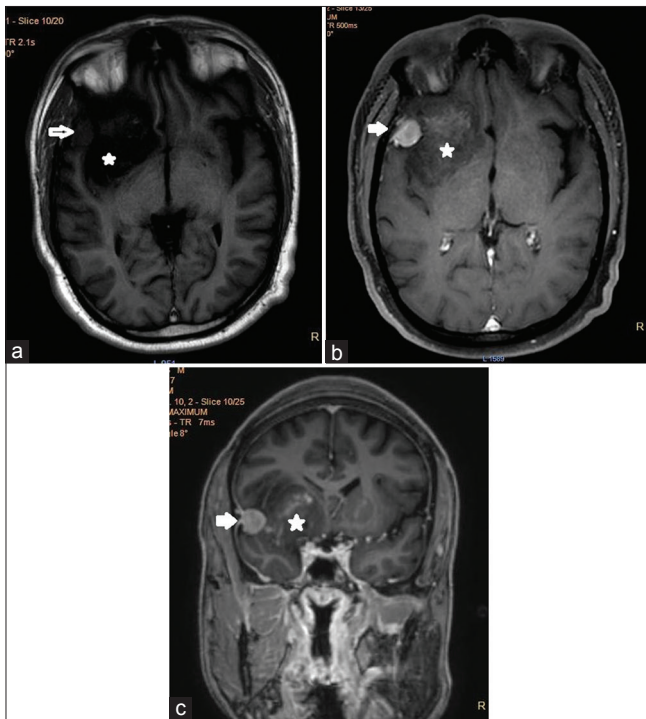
(a) Magnetic resonance imaging brain T1-weighted image showing a hypointense right insular lesion (asterisk) and an isointense dural-based lesion (arrow). (b and c) Contrast Magnetic resonance imaging image showing strongly enhancing dural-based lesion suggestive of a meningioma (arrow) and an heterogeneously enhancing lesion in right insular region suggestive of a glioma (asterisk)
